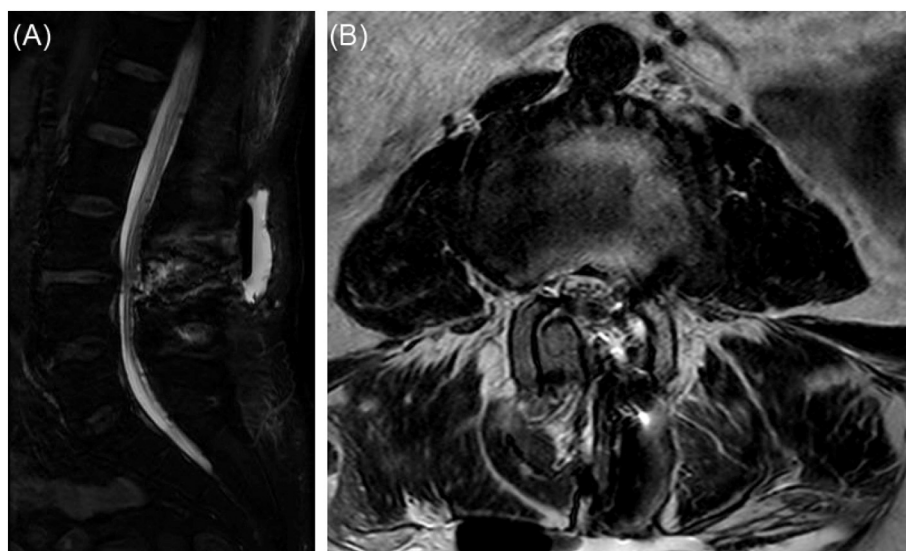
Sagittal (A) and axial (B) T2-weighted lumbar spine MRI showing post-operative soft tissue changes with multiple gas bubbles and elongated thin-walled fluid collection overlying the paravertebral muscle at the site of the surgery measuring about 11.8 * 1.5 * 8 cm, containing air fluid level.
